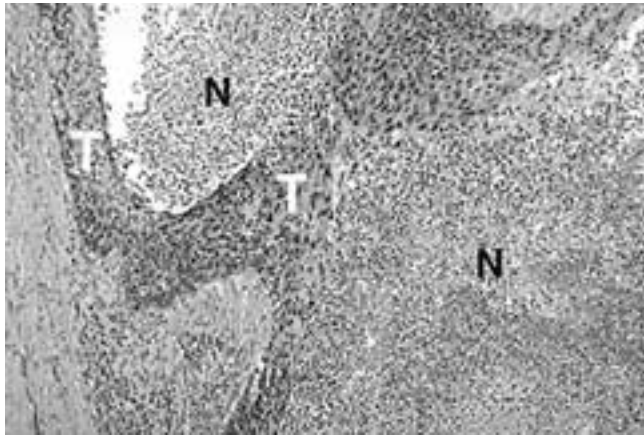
There are ribbons of viable tumor (*T*) within this metastatic lymph node, with shedding of necrotic cells (*N*). This is seen as central necrosis on CT and MR imaging.
